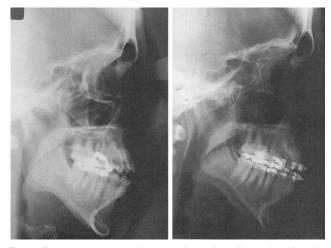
Pre- and postoperative cephalometric radiographs. Note the increased posterior airway space.
